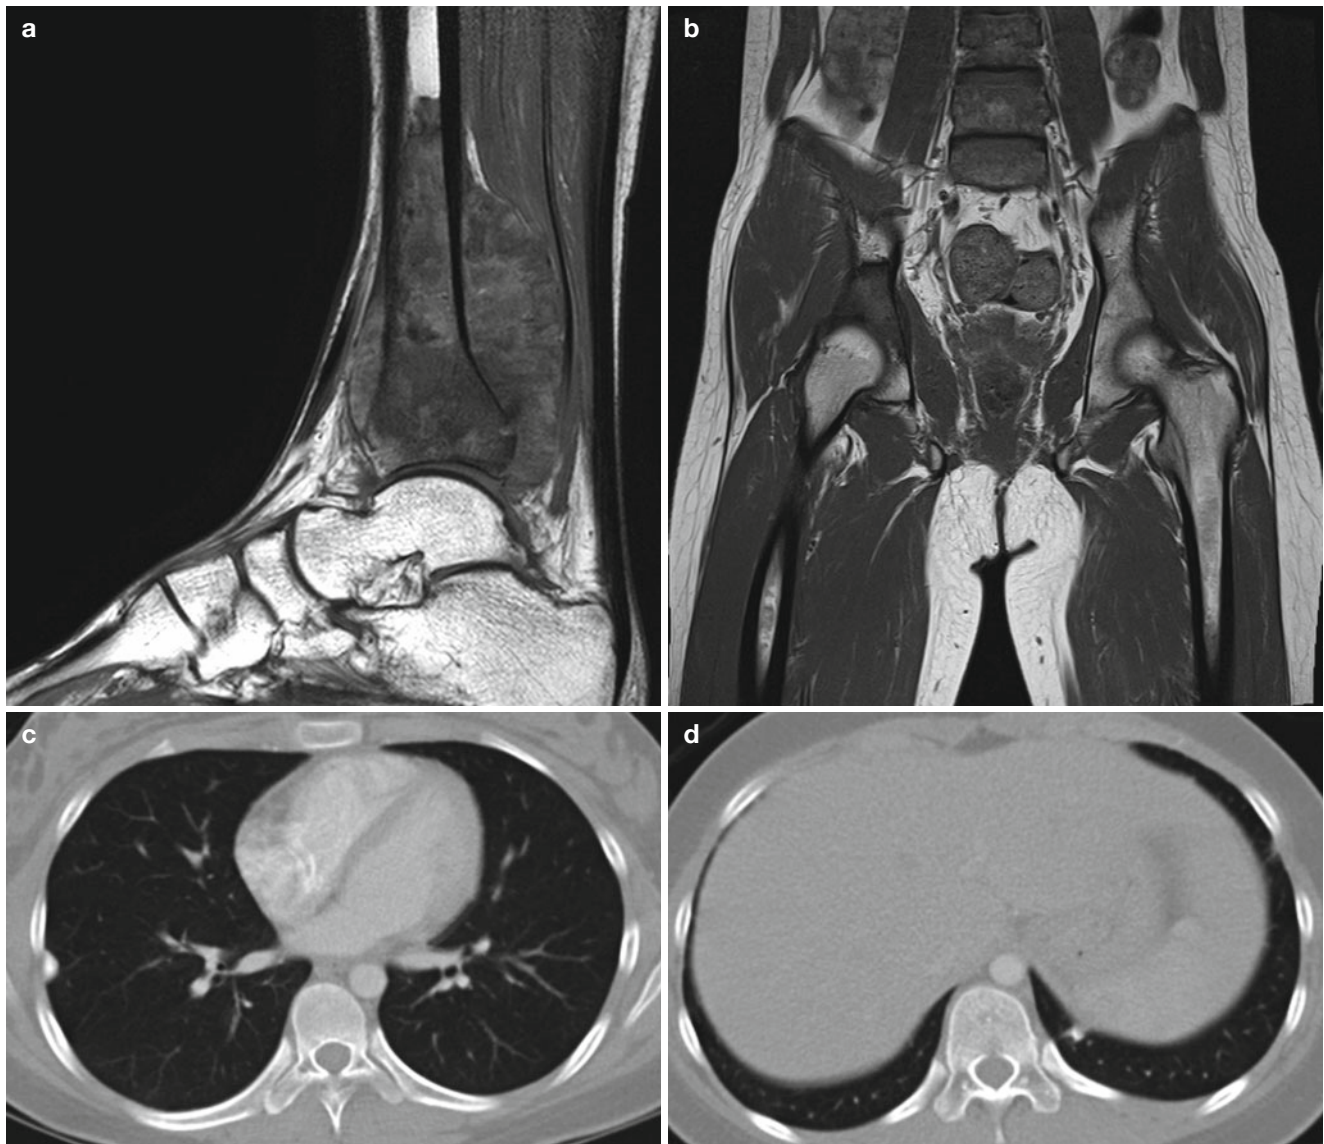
Osteosarcoma with pelvis and lung metastasis.* (a) Intraosseous and extraosseous tumor representing osteosarcoma in the left distal tibia on T1-weighted sagittal image. (b) Low signal intensity bony lesion is seen in the right acetabulum on precontrast T1-weighted
